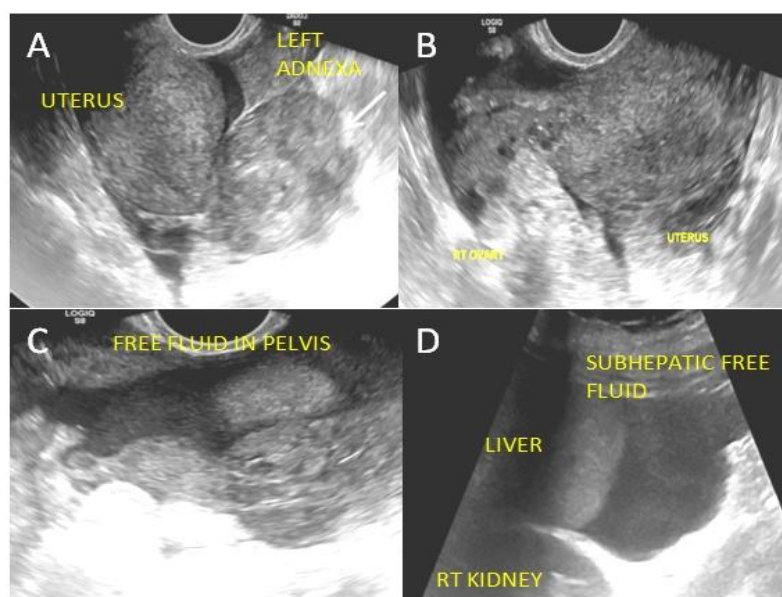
Transvaginal ultrasound - longitudinal (A) and transverse (B, C) images show heterogeneous lesion in left adnexa (arrows) with free fluid showing fine floating internal echoes in pelvis. Uterus and right ovary appear normal. On transabdominal image (D) moderate free fluid with fine echoes was seen in abdomen (subhepatic region)
